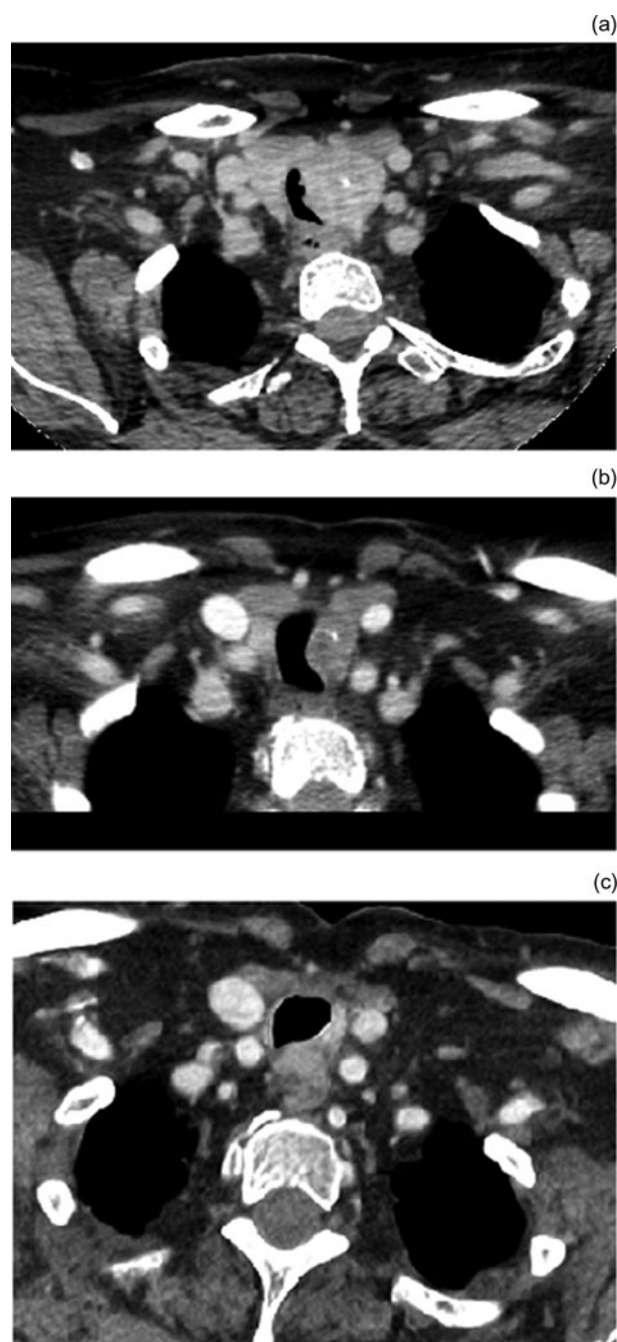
Case 1. Computed tomography showing: (a) axial plane image of left thyroid mass at presentation, (b) axial plane image showing 82 per cent tumour volume reduction after 14 months of tyrosine kinase inhibitors and (c) axial plane image of stable mass appearance after 3 years.
